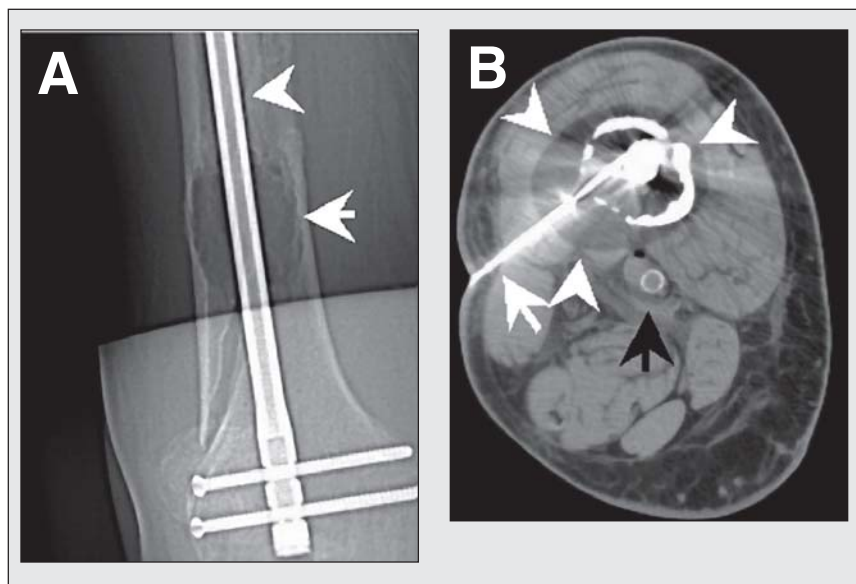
Right Femur, Percutaneous CT-Guided Placement of Three Cryoprobes—(A) Plain-film radiograph of right femur demonstrates an intramedullary rod (arrowhead) across an osteolytic destructive mid-diaphyseal metastasis (arrow) with a pathologic fracture. (B) Axial CT image shows that the iceball (white arrowheads) generated by the percutaneously placed probes (white arrow) encompasses the destructive lesion without involving adjacent vessels and nerves (black arrow). A small amount of gas adjacent to the femoral vein resulted from instillation of a small amount of saline in this region. The patient was unable to walk more than a short distance with the assistance of a cane prior to the procedure, with worst pain of 8/10. Twelve weeks following cryoablation treatment, he was able to walk without a cane, with worst pain of 3/10. CT = computed tomography.
